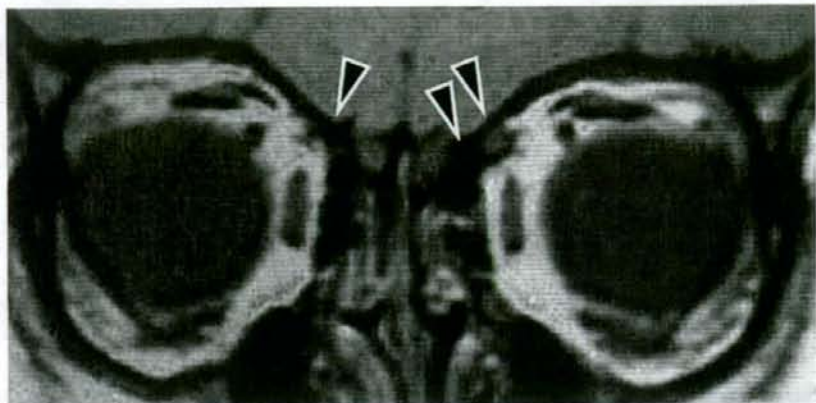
Coronal magnetic resonance imaging scan from a 2-year-old boy with class III superior oblique tendon anomaly (Case 2). The black triangles indicate superior oblique tendons. The right superior oblique tendon is markedly hypoplastic.
